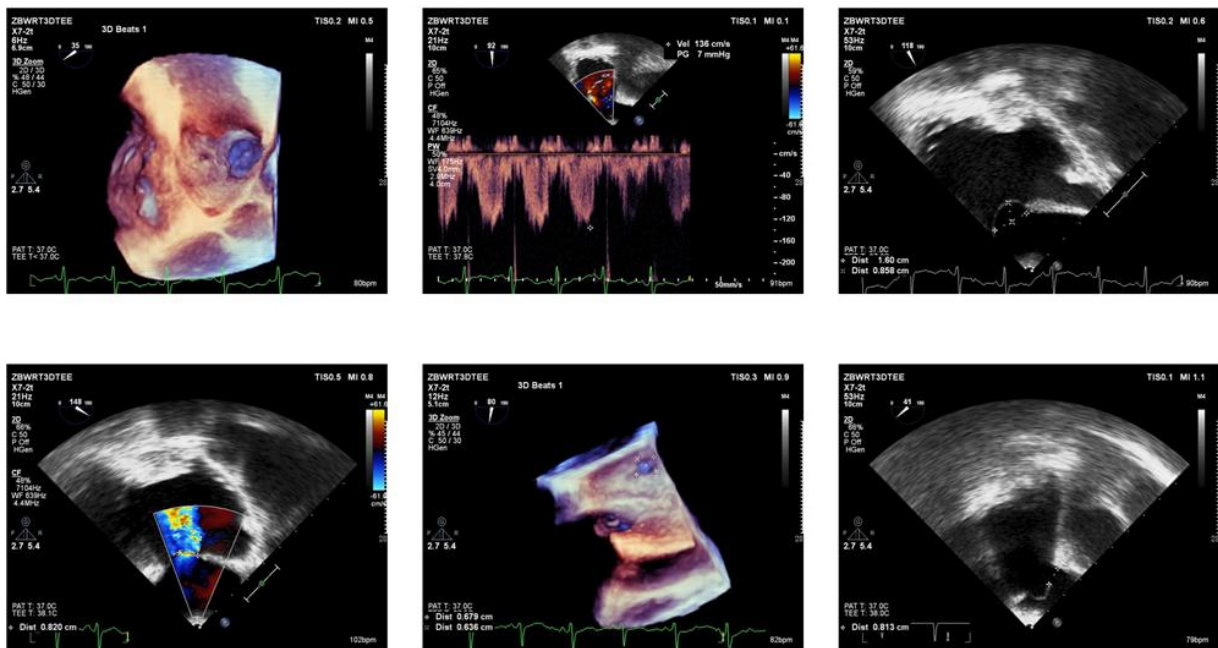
Preoperative real-time three-dimensional transesophageal echocardiography revealed showed an oval defect of 6.79×6.36 mm in the middle of the atrial septum.
